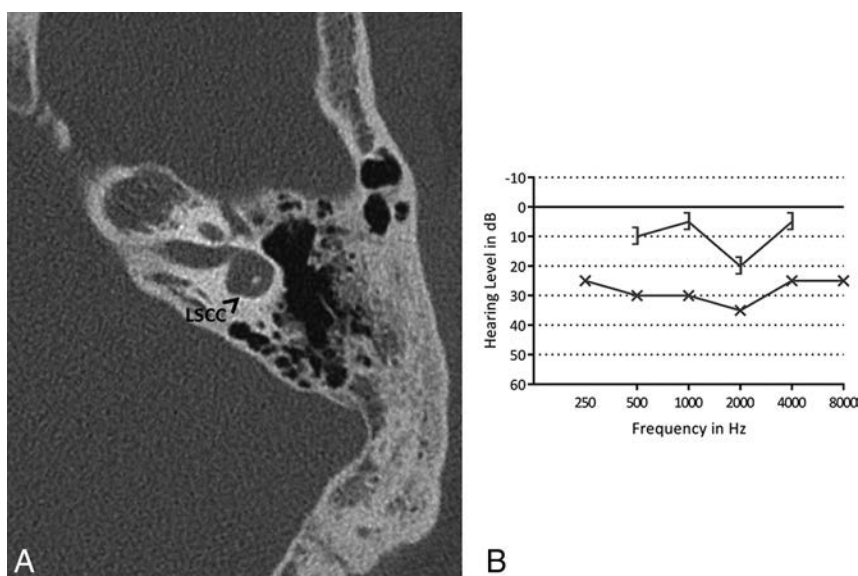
A, Axial CT image of left mastoid bone shows the lateral semicircular canal with a small bony island. B, A pure tone audiogram of the same ear shows a mild conductive hearing loss. The x indicates an unmasked air-conduction threshold; the bracket, a masked bone-conduction threshold.
